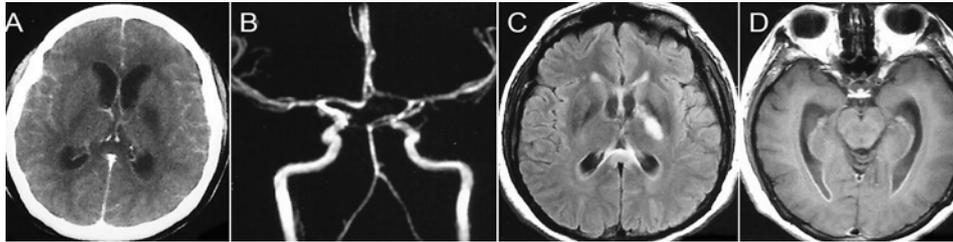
Contrasted CT scan on admission shows hydrocephalus, a left capsular infarction and abnormal insular gyral enhancement.
